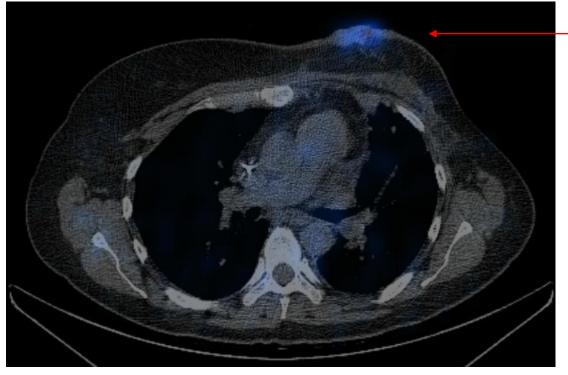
SPECT imaging using Technetium-99m. A) Patient COH-004 received CF33-hNIS-antiPD-L1 at DL2 (3x10<sup>5</sup> PFU). Injected lesion was left axillary lymph node. SPECT imaging showed enhancement of injected lymph node (red arrow). B) Patient COH-008 received CF33-hNIS-antiPD-L1 at DL3 (1x10<sup>6</sup> PFU). Injected lesions were superior left chest wall nodules. Injected nodules demonstrated necrosis on clinical exam (red oval). SPECT imaging showed enhancement of injected nodules (red arrow).
